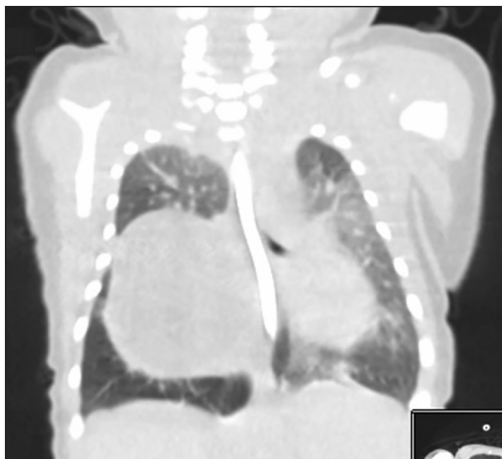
Coronal computed tomography with contrast demonstrating right intra-thoracic mass causing mediastinal shift to the left and obstructive emphysematous changes of right lower and middle lung
